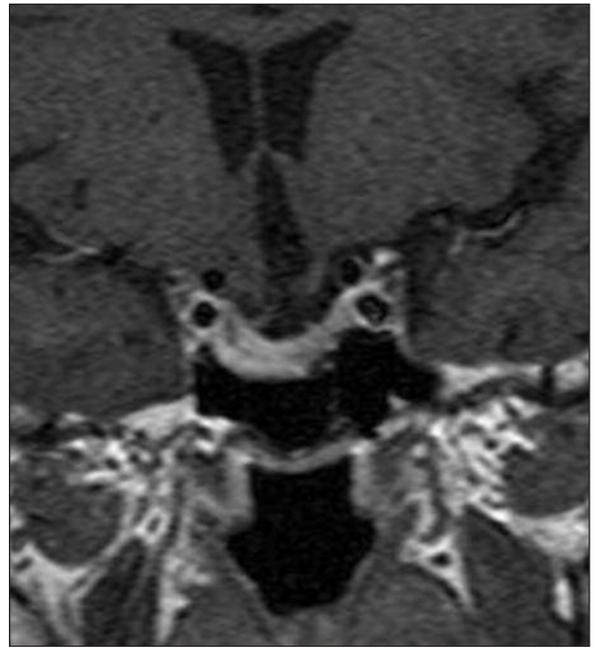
Pituitary MRI (coronal contrast-enhanced T1 weighted image). Control visit.
